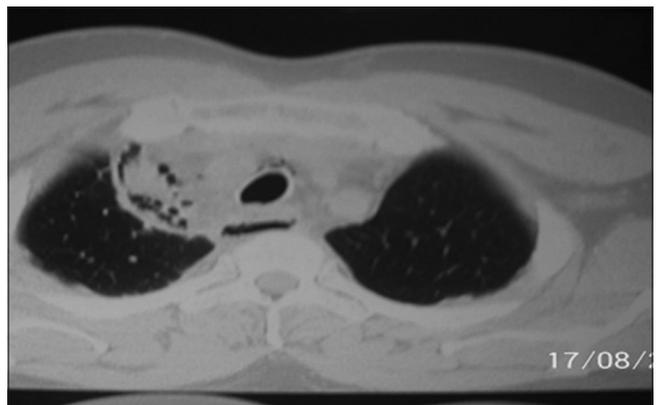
Computed tomography chest showing multiple air pockets in left mediastinum indicating pneumomediastinum
